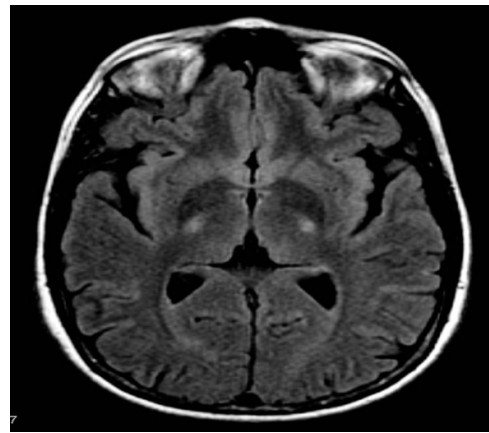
MRI (axial FLAIR) demonstrates increased T_2 signal within the posterior part of the internal capsule, consistent with the diagnosis of ALS.³⁹
